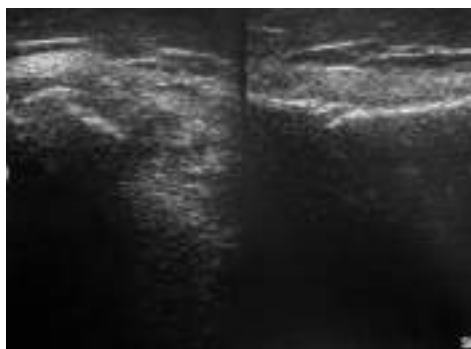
Ultrasonographic presentation of the distraction site of tibia: Non-completed hyper-reflecting solid line in transversal plane and invaginated cortical margin in longitudinal plane at the beginning of the consolidation stage
